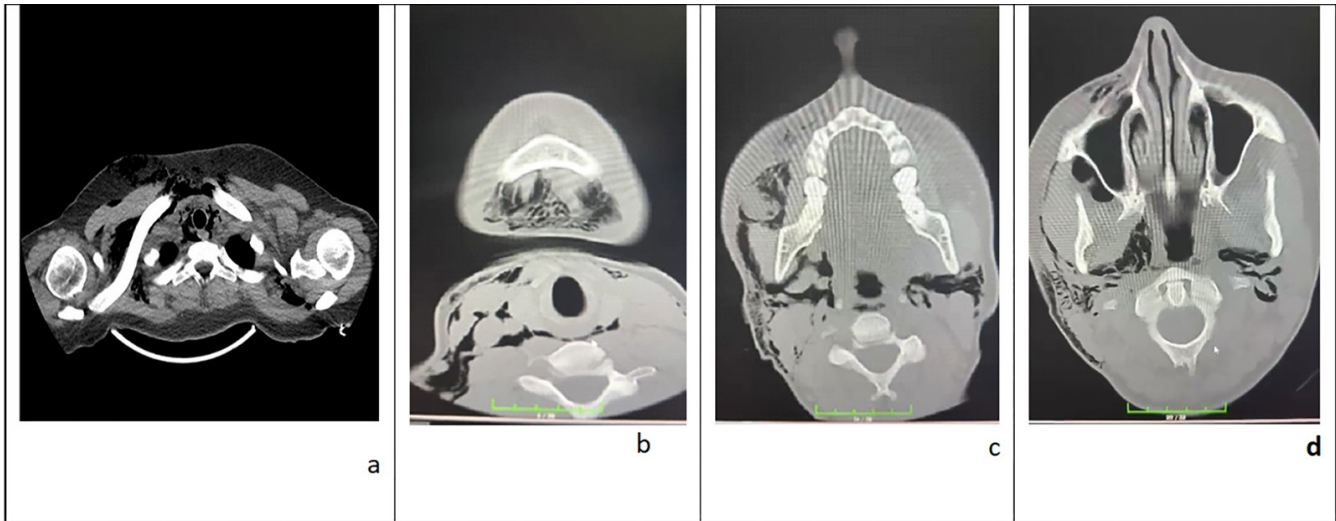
Computed tomography images showing (a,b) air densities extending from the mediastinal area into the subcutaneous tissues between the cervical muscle layers, including the retropharyngeal, submandibular, and sublingual spaces, as well as along the upper posterior and anterior thoracic walls and the posterior mediastinum; (c,d) subcutaneous emphysema more prominently involving the right side of the neck, extending into the bilateral parapharyngeal, masticator, and parotid spaces, the right temporal fossa, posterior cervical triangle, and nasopharyngeal spaces, surrounding the adjacent vascular structures
